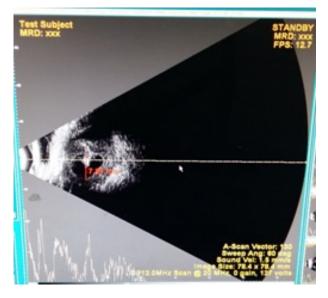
On Ultrasound Bscan orbit of left eye using a water bath, a well-defined cystic lesion measuring 7.87 mm vertically and 8.70 mm horizontally with a hyperechoic high intensity spike on upper wall of the cyst suggestive of cysticerosis cyst with scolex.
